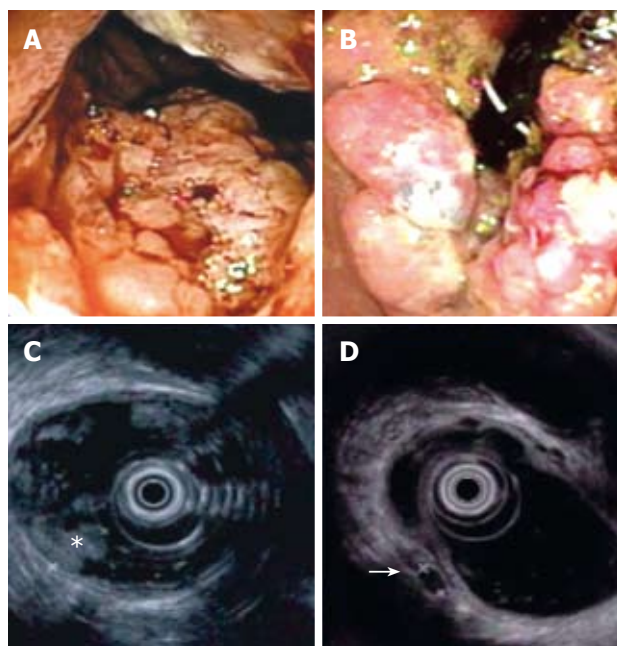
Colonoscopy demonstrates. A: Large sessile polypoid growth with velvety surface and superficial ulceration in the rectum (forward view); B: Multilobulated, smooth surfaced exophytic nature of the tumor upon retroflexion. Sonographic images at rectal EUS showing; C: An infiltrative mass with invasion of the muscularis mucosa (star); D: An 8-mm hypoechoic lymph node suspicious for lymphatic metastasis (arrow).
